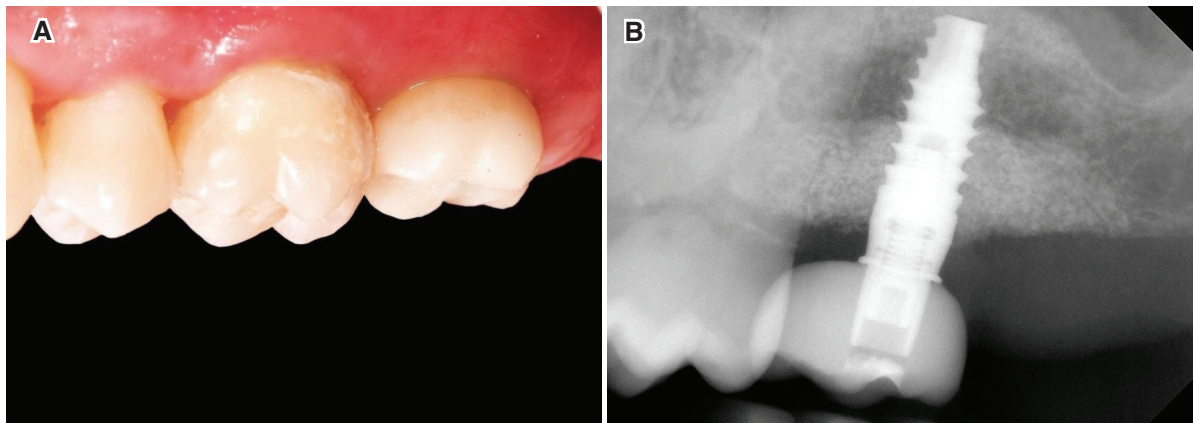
The 18-month follow-up. (a) The clinical situation appeared stable, with no recession or local inflammation. (b) The periapical X-ray showed no pathologic alterations with periimplant tissue stability.
